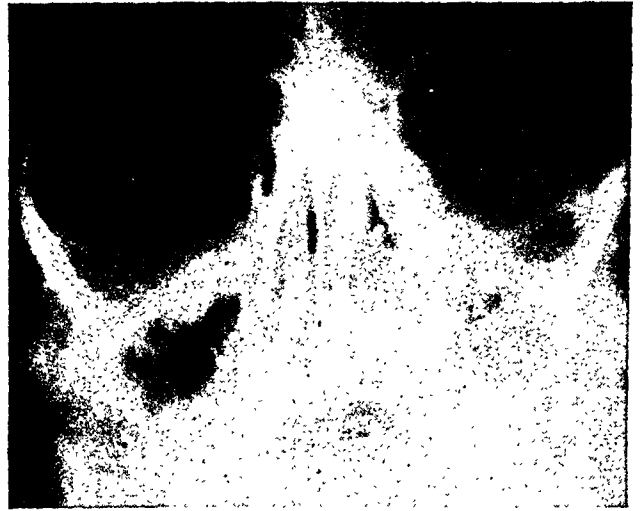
(Bikle and Levitt). X-ray picture of orbits showing smallness of right orbit.
